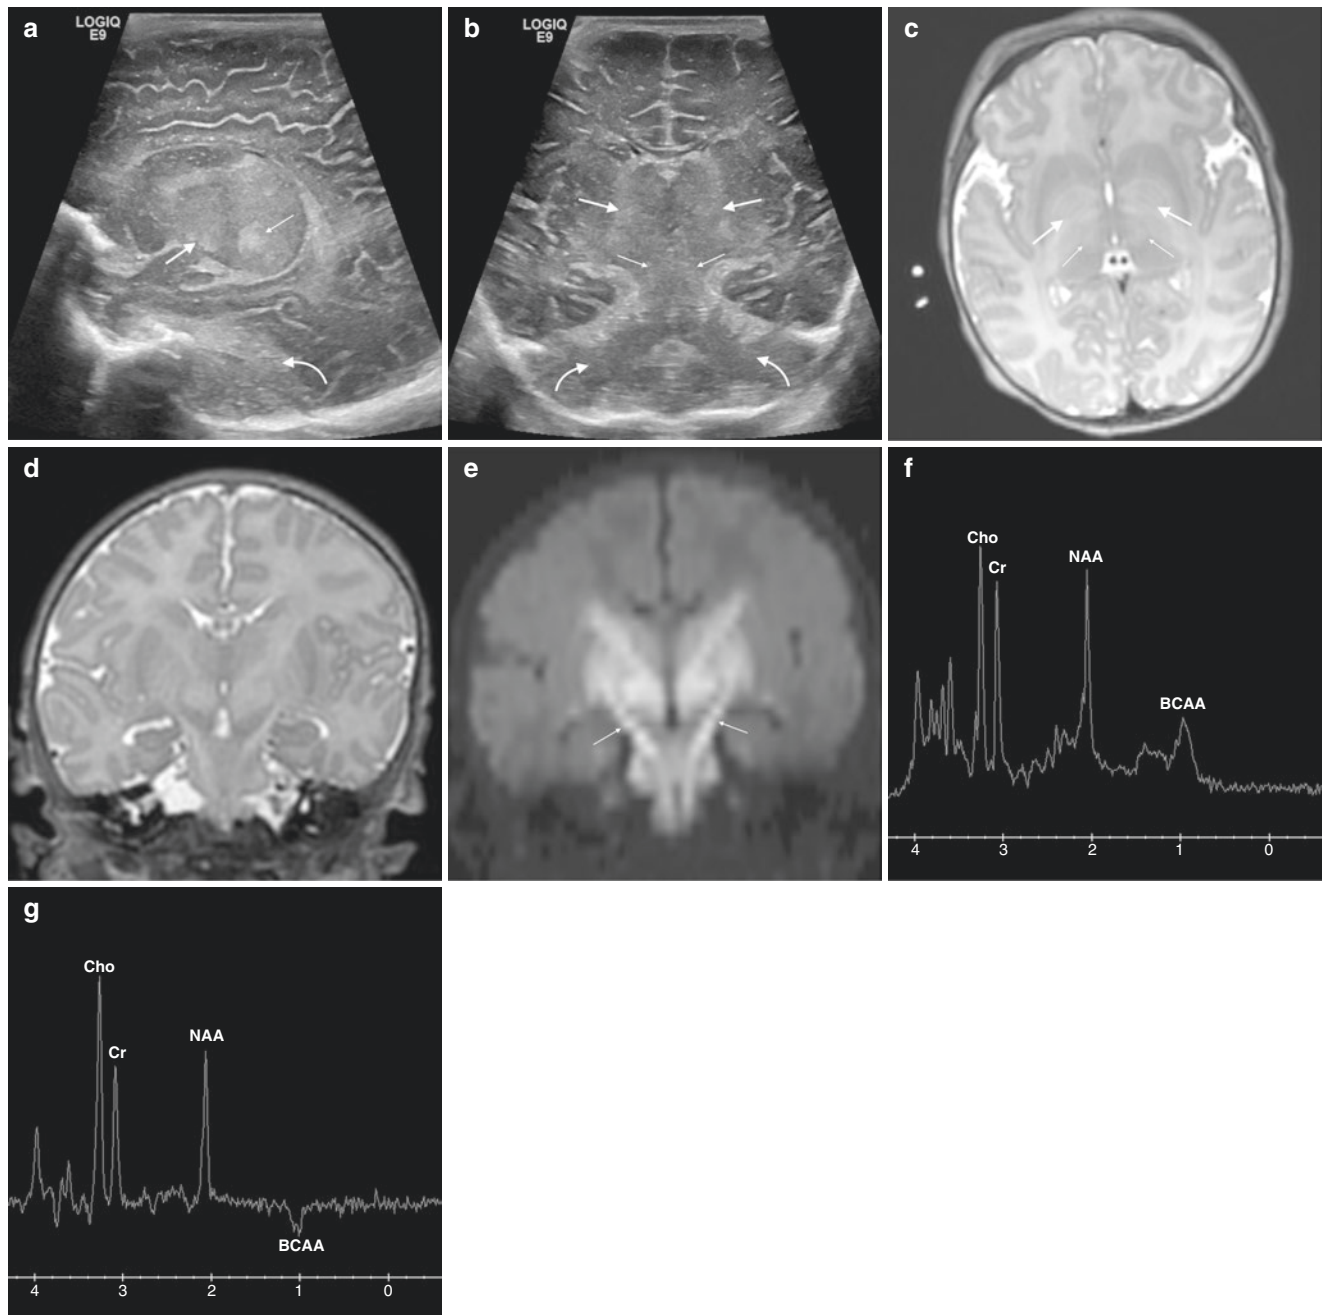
Neonatal female with maple syrup urine disease (MSUD). (a) Parasagittal gray-scale ultrasound image of the brain shows abnormal hyperechogenicity in the cerebral white matter, lentiform nuclei (thick arrow), thalamus (thin arrow), and imaged cerebellum representing edema (curved arrow). (b) Coronal gray-scale ultrasound image of the brain shows thalamic (thick arrows), brainstem (thin arrow), and cerebellar (curved arrow) hyperechogenicity representing edema. (c) Axial T2-weighted MR image (TR/TE msec, 2500/65) through the basal ganglia depicts abnormal hyperintense signal in parts of the globi pallidi (thick arrows), thalami (thin arrows), and white matter. Coronal T2WI
